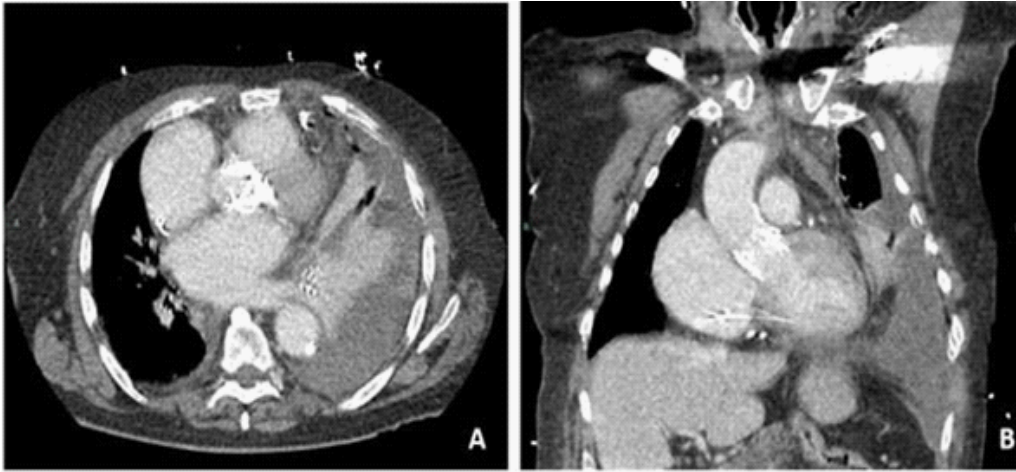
CT scan shown the presence of left pleural effusion and subtotal collapse of ipsilateral lung. The hemorrhage is also observed in the left part of anterior mediastinum (Panel A: axial plane; Panel B: coronal plane).
